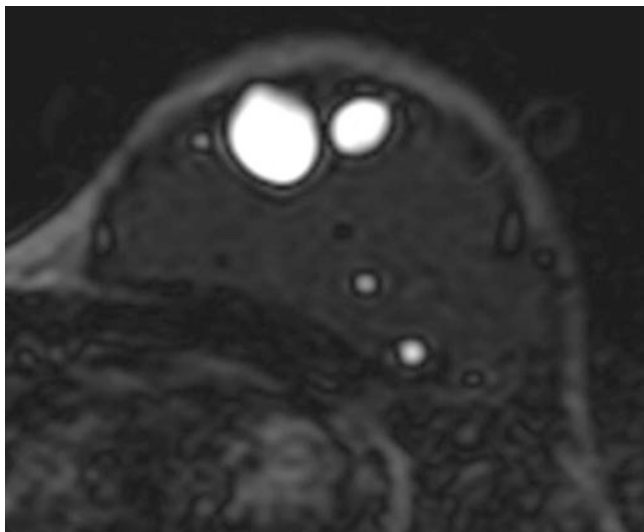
Breast MRI with black silicone sequence: teardrop sign. The silicone appears completely black, and inside there are some white images due to water
